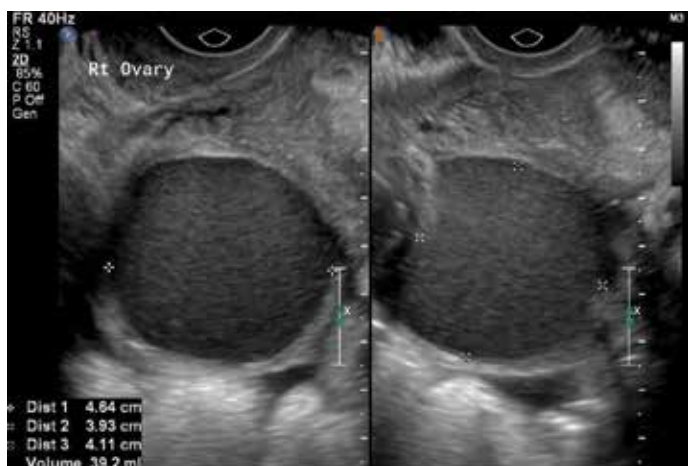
Endometrioma. Transvaginal ultrasound demonstrates a right ovarian lesion with homogeneous low level internal echoes. In this patient, a similar lesion was also present in the contralateral ovary.
